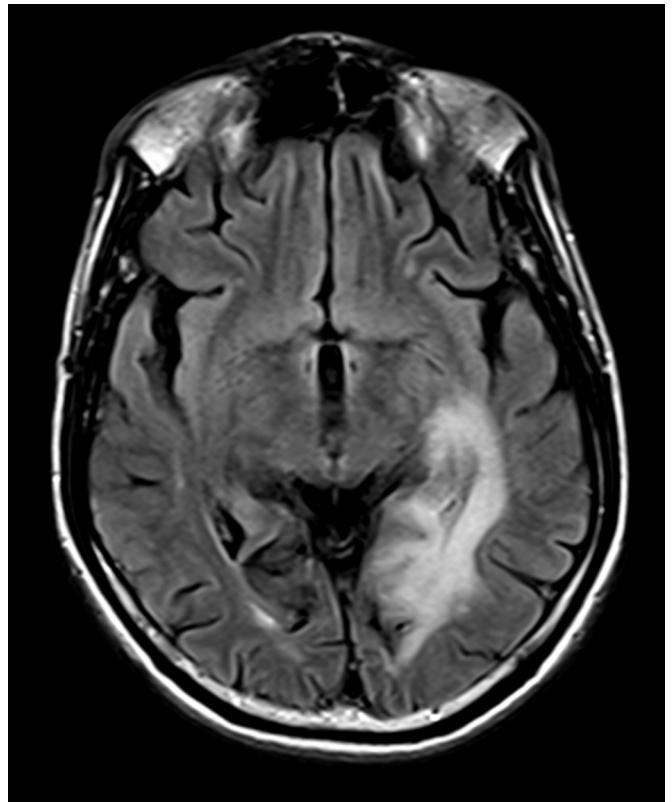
■ FLAIR MRI showing PML with immune reconstitution inflammatory syndrome (IRIS) in a patient with human immunodeficiency virus (HIV) following institution of antiretroviral therapy. There is edema in and surrounding a lesion within the left posterior cerebral white matter.
